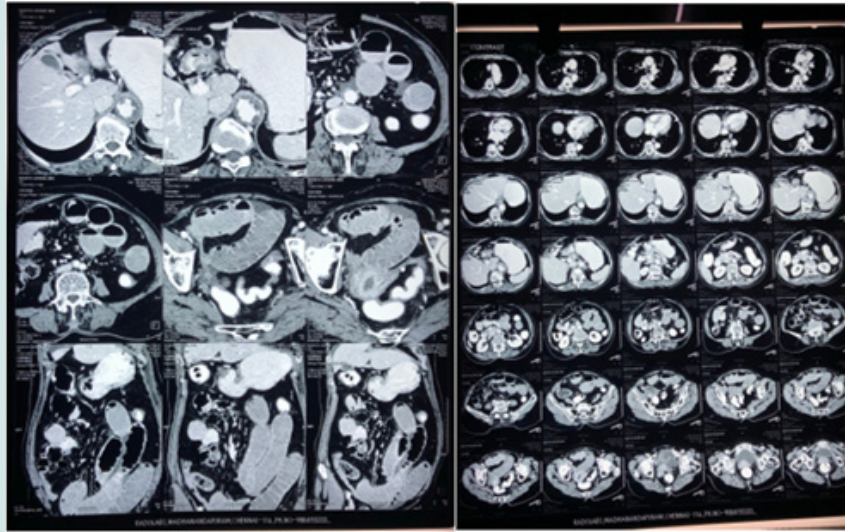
CT showed dilated small bowel loops with multiple air fluid levels with transition point at the mid ileum.
